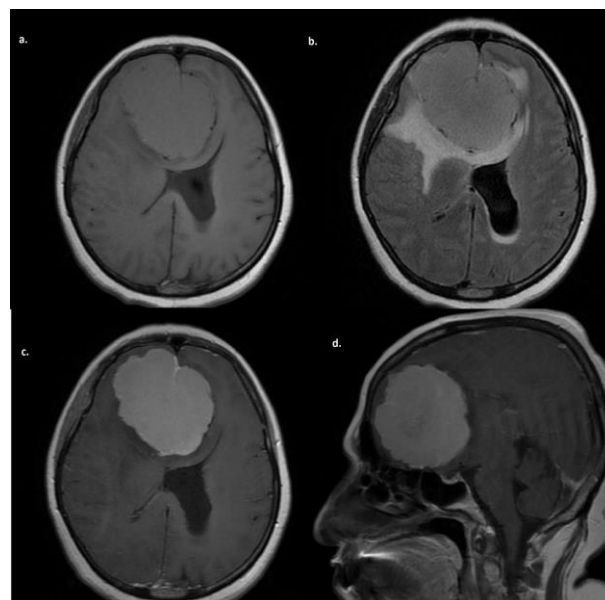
Preoperative brain MRI examination: The images without contrast are axial T1-weighted (a) and axial T2-FLAIR-weighted (b) MRI scans. There is compression of the lateral ventricle and genu segments of corpus callosum. There is intense vasogenic edema around the mass in the axial T2 FLAIR-weighted MRI scan. It shows intense homogeneous enhancement in contrast-enhanced axial T1-weighted (c) and sagittal T1-weighted (d) MRI scans.
